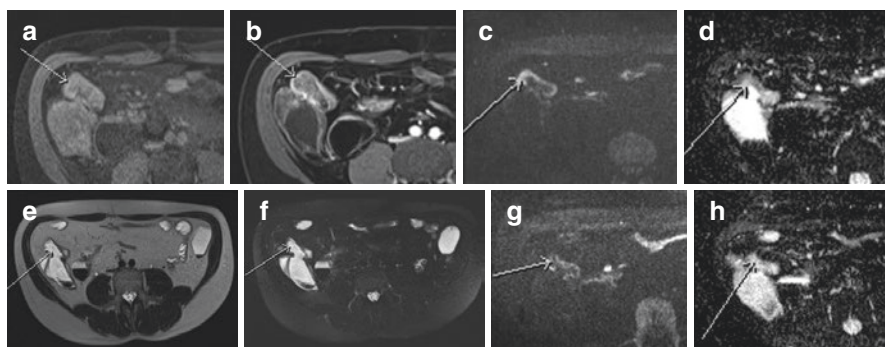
Changes in DWI following treatment. There is mildly thickened and active neo-terminal ileal activity in a Crohn's patient with an ileo-colonic anastomosis shown on pre- (a) and post-contrast (b) fat saturation T1 sequences and DWI $B = 600 \text{ s/mm}^2$ (c) with moderately restricted diffusion on the ADC map with (d). Subsequent follow-up 2 years later (e–h) demonstrates improved features with no mural oedema on fat sat HASTE sequence (f), reduced signal on DWI (g) and less restricted diffusion (h)
